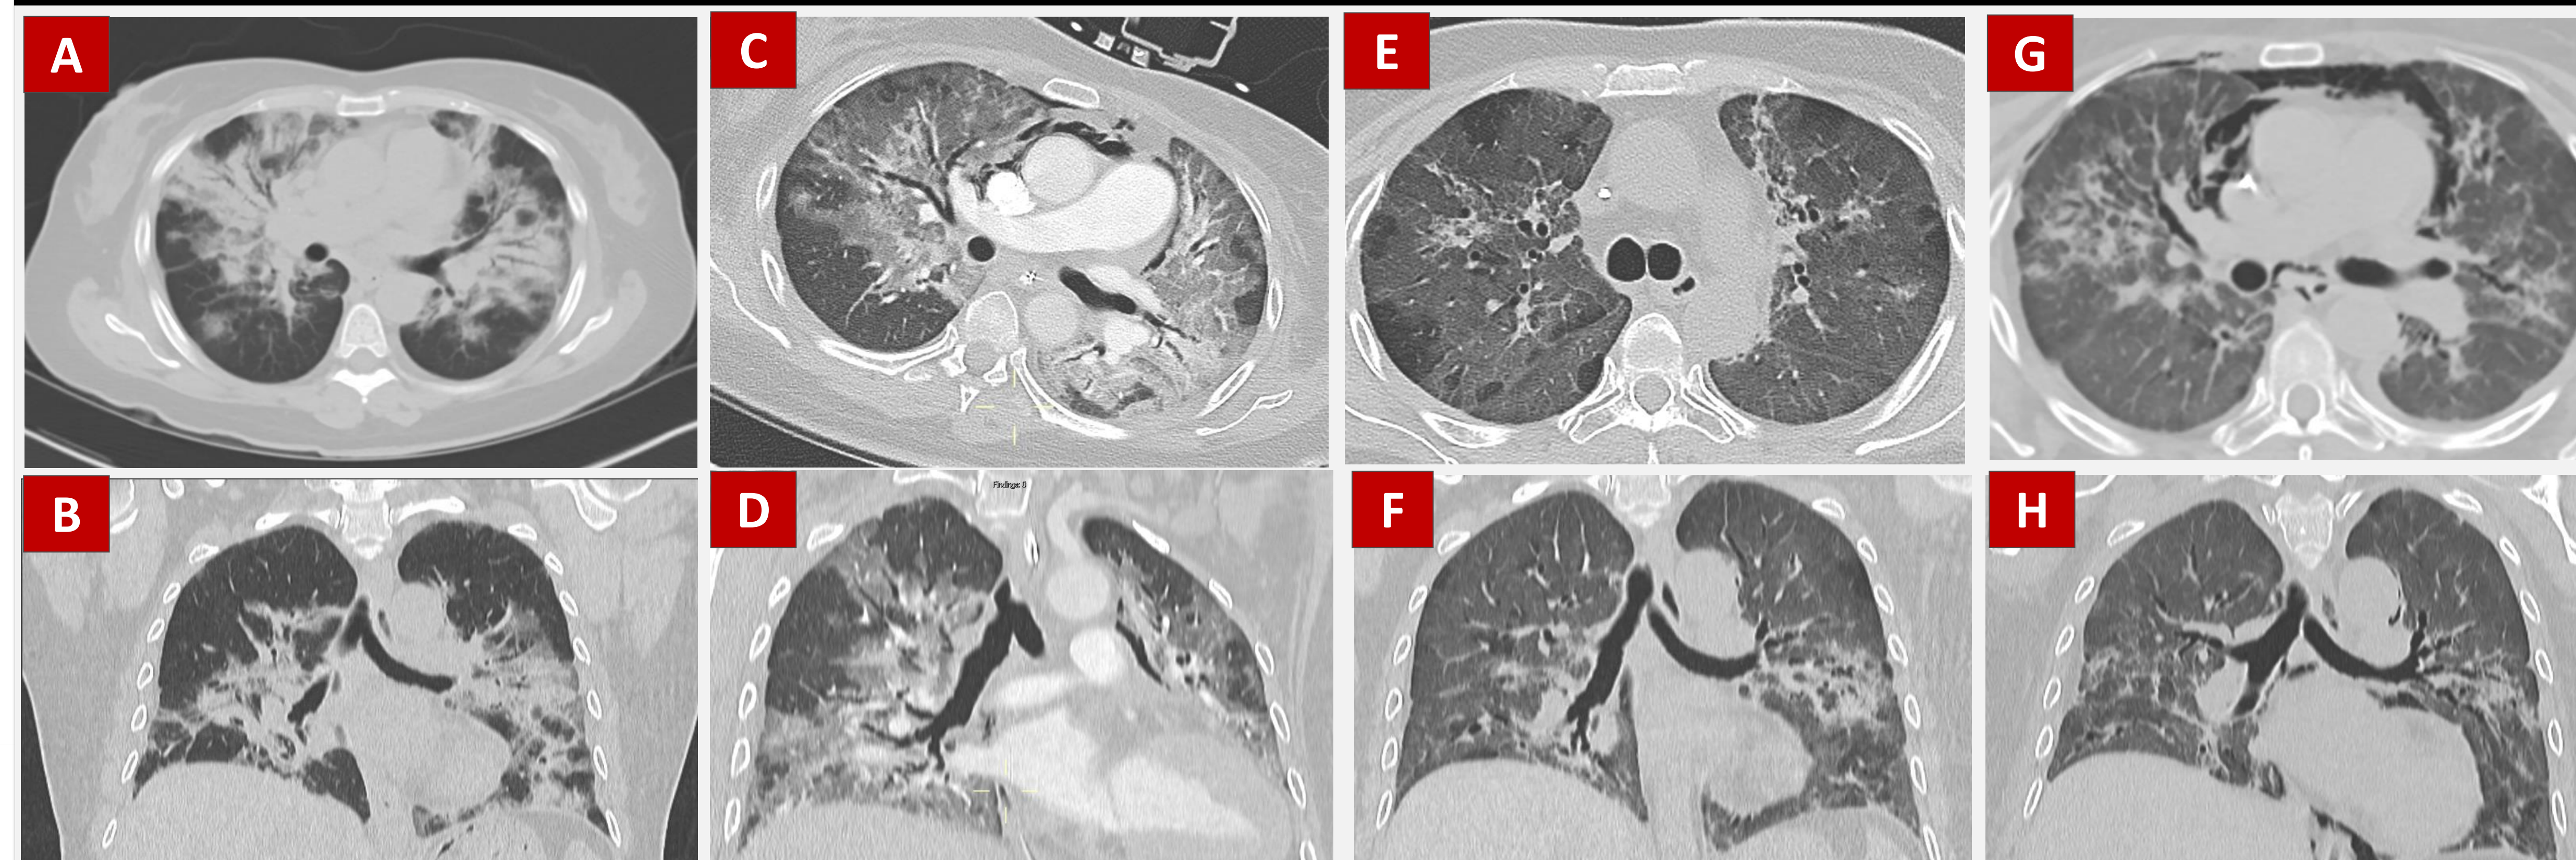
Cross sectional and coronal CT chest images on admission (A&B), week 1 (C&D), week 3 (E&F), week 4 (G&H)
